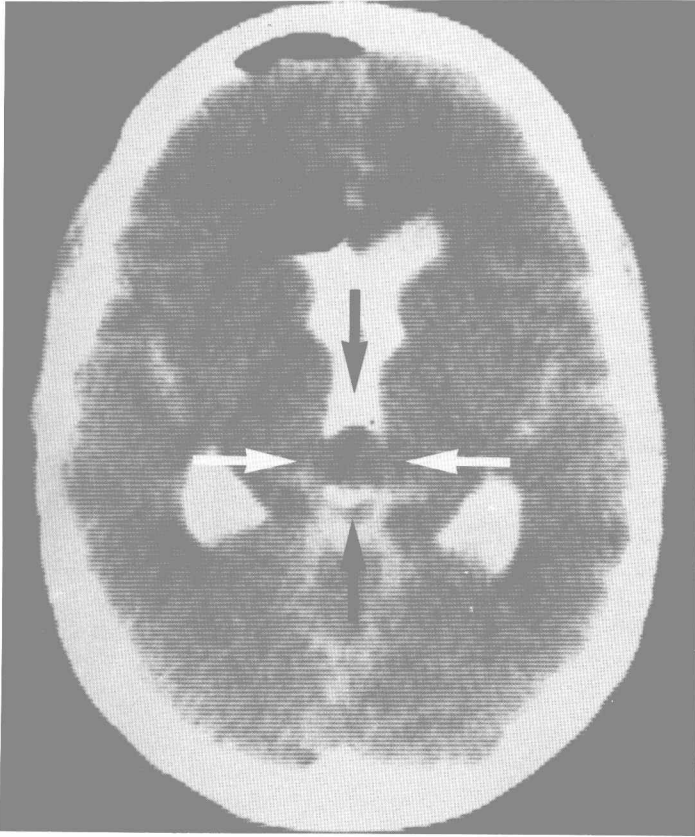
Preoperative transaxial CT metrizamide ventriculogram at the level of the lateral ventricles demonstrating a spherical pineal region mass (*arrows*). The low density in the left anterior lateral ventricle is air. (From Neuwelt EA, Levy A: *New England Journal of Medicine*. 308:1132–1135, 1983 (33).)
